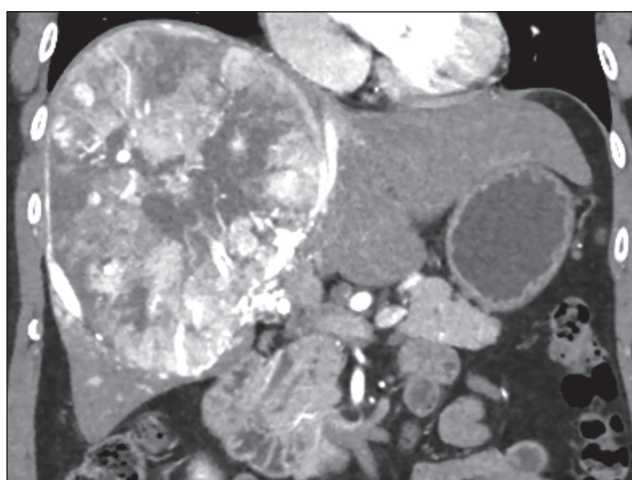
Coronal reformat of arterial-phase CT shows replacement of the right lobe with a large hepatocellular carcinoma, extending into segments 1 and 4.
